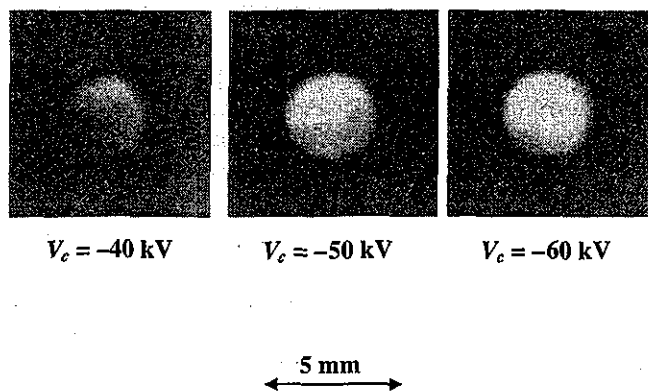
Images of X-ray source with changes in charging voltage at constant space between target and cathode electrodes.
